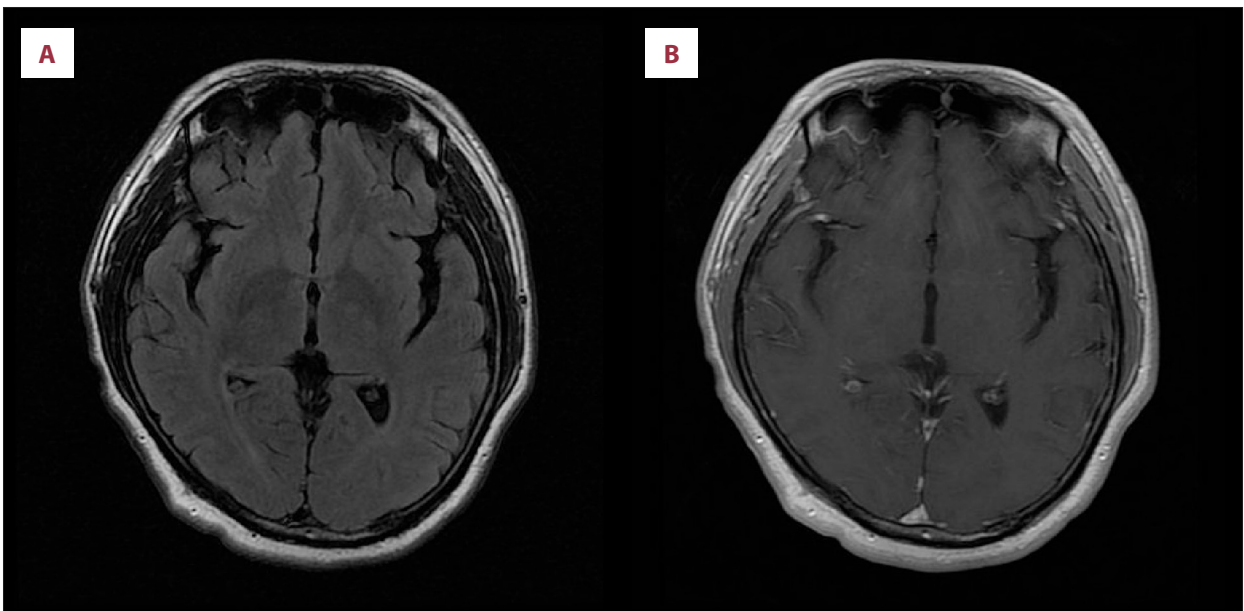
Brain magnetic resonance imaging (MRI) findings after 6 weeks of IV ceftriaxone. (A) Fluid-attenuated inversion recovery (FLAIR). (B) Post-contrast, 9 mL of gadobutrol (Gadovist).
